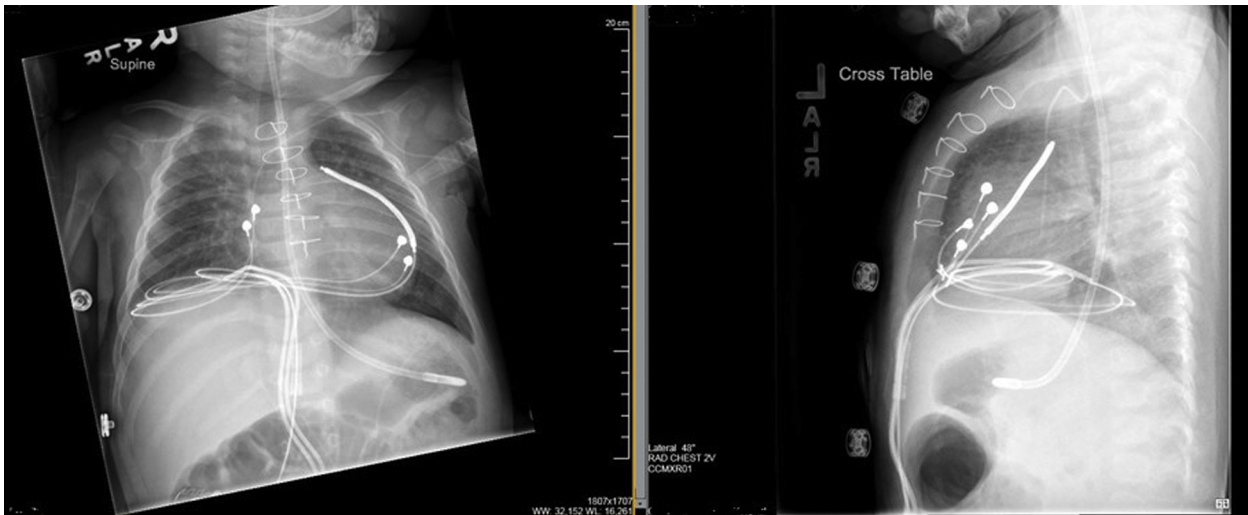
Chest radiograph post implantable cardioverter-defibrillator implantation.
